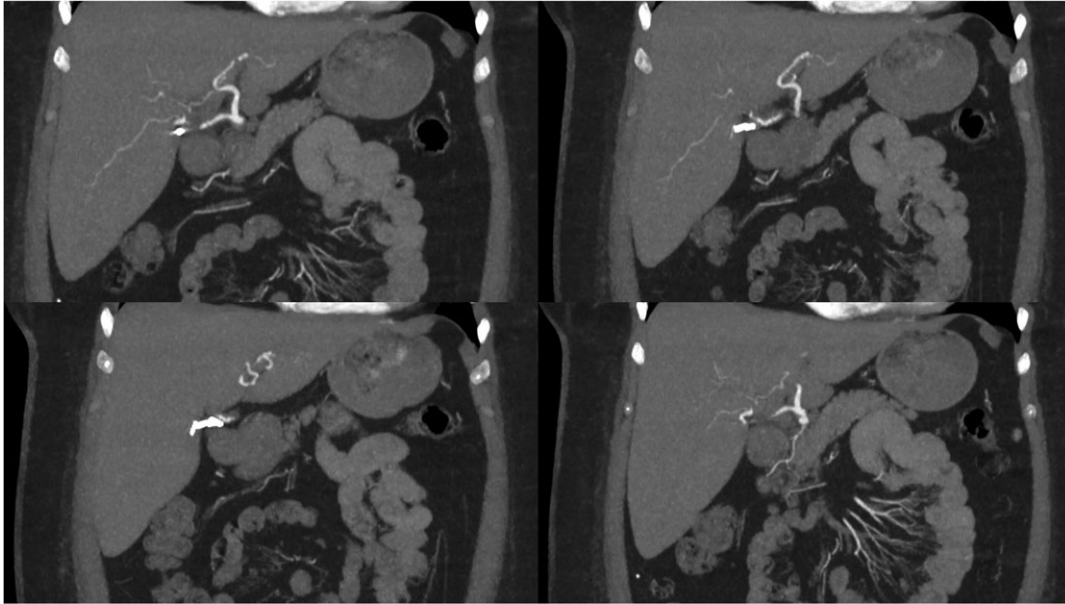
Contrast CT series demonstrating normal intrahepatic arteries.
